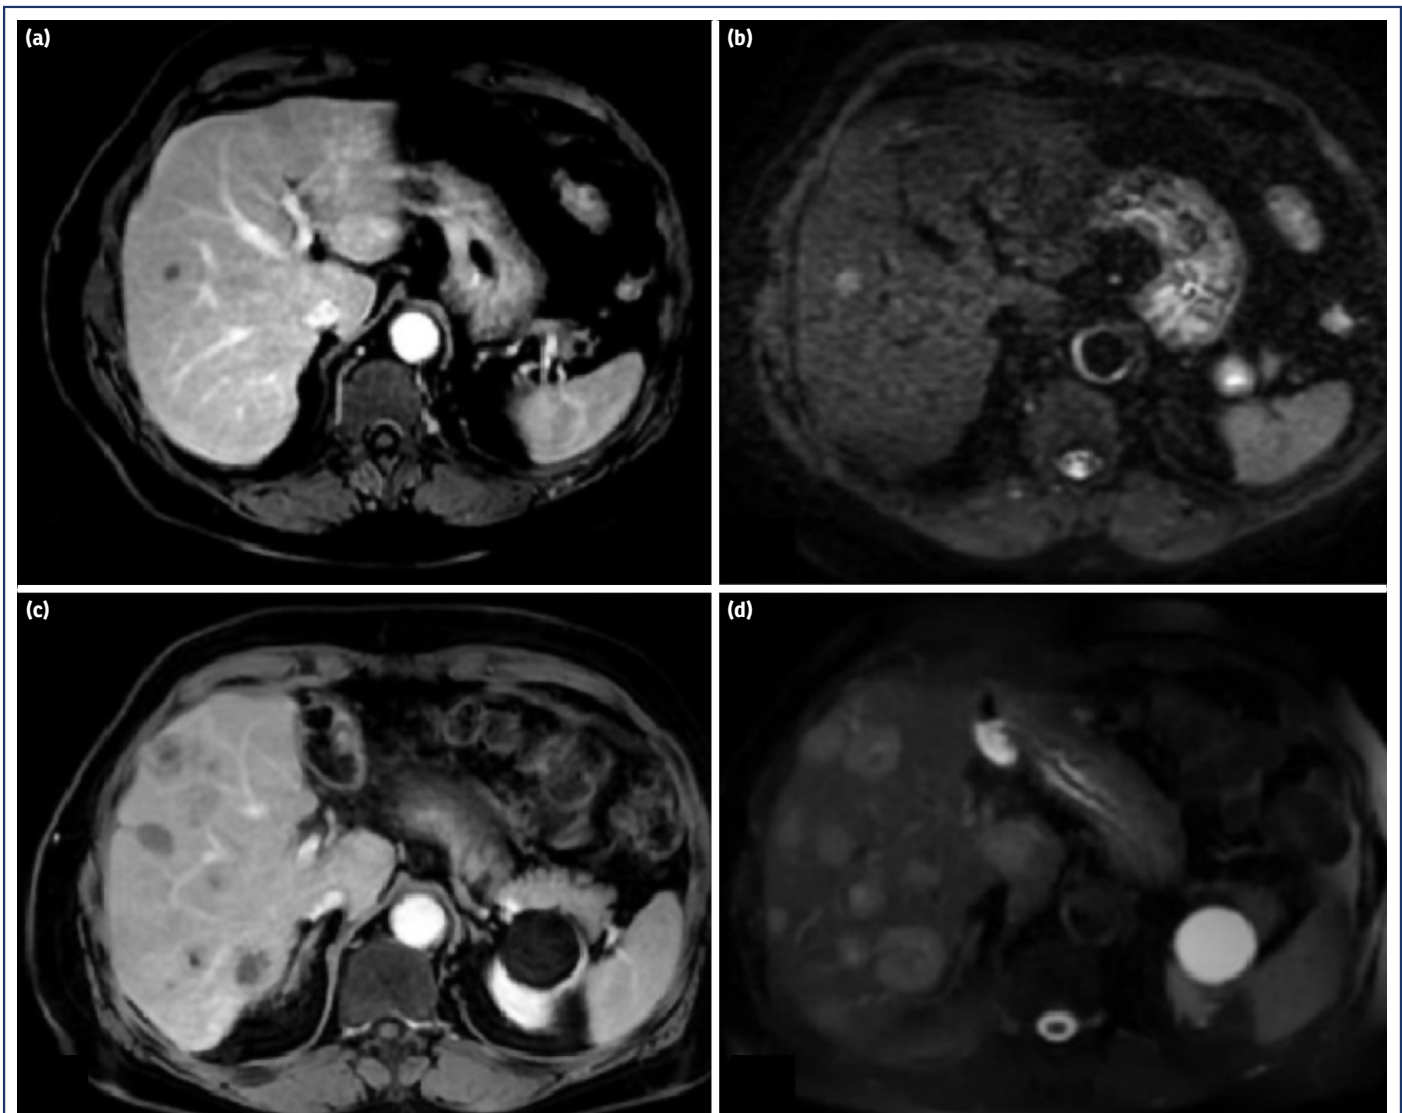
The dynamic contrast enhanced magnetic resonance imaging of a 65-year-old, male with metastatic liver tumor. Intraoperative microwave ablation (MWA) therapy was performed. Before the MWA therapy; axial portal phase T1W (a) and DWI (b) images showed an metastatic mass in segment 8. 3 months after the MWA therapy; Pathological enhancement was not observed at the ablation site, but multiple intrahepatic distant metastases were revealed in the parenchyma (c), Fat suppressed-T2W images from the upper parts of the ablation site showed other metastatic masses (d).
